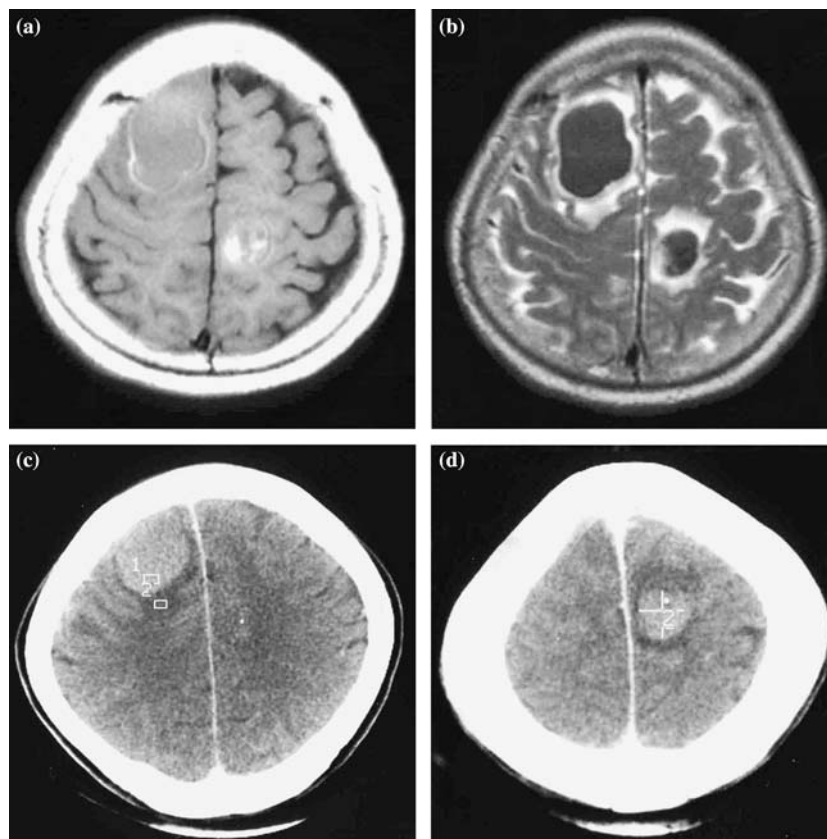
Radiological findings of multiple hemorrhagic brain metastases in case 6 (a & b; Brain MRI, c & d; Brain CT). The simultaneous occurrence of hemorrhagic events can lead to assume that some metastatic brain tumors have a tendency to bleed as basic characteristics.
